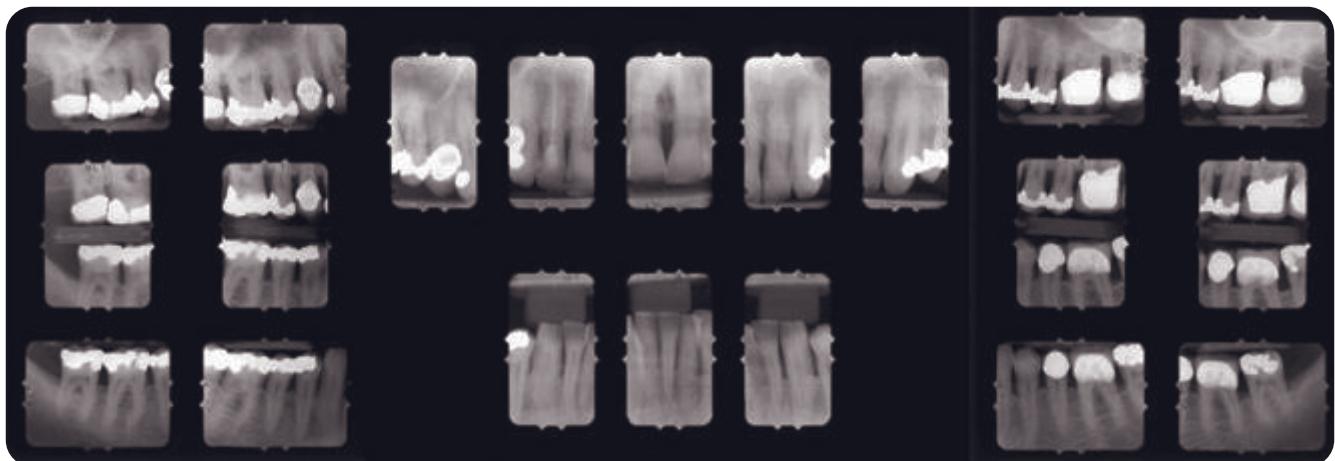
Pretreatment full mouth radiographic series suggesting structural condition of the posterior teeth and the poor condition of the supporting osseous structures.
